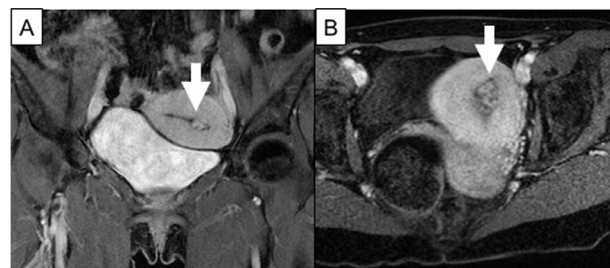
A 38-years-old female with menometrorrhagia and history of 2 abortions with dilation and curettage. T2-weighted MR (A) in coronal plane, white arrow showing a serpiginous vascular structure in the uterine wall and cavity (white arrow); contrast-enhanced T1-weighted MR (B) in axial plane acquired in precocious arterial phase showing a focal area of tubular enhancement (white arrow) corresponding to the acquired AVM.
